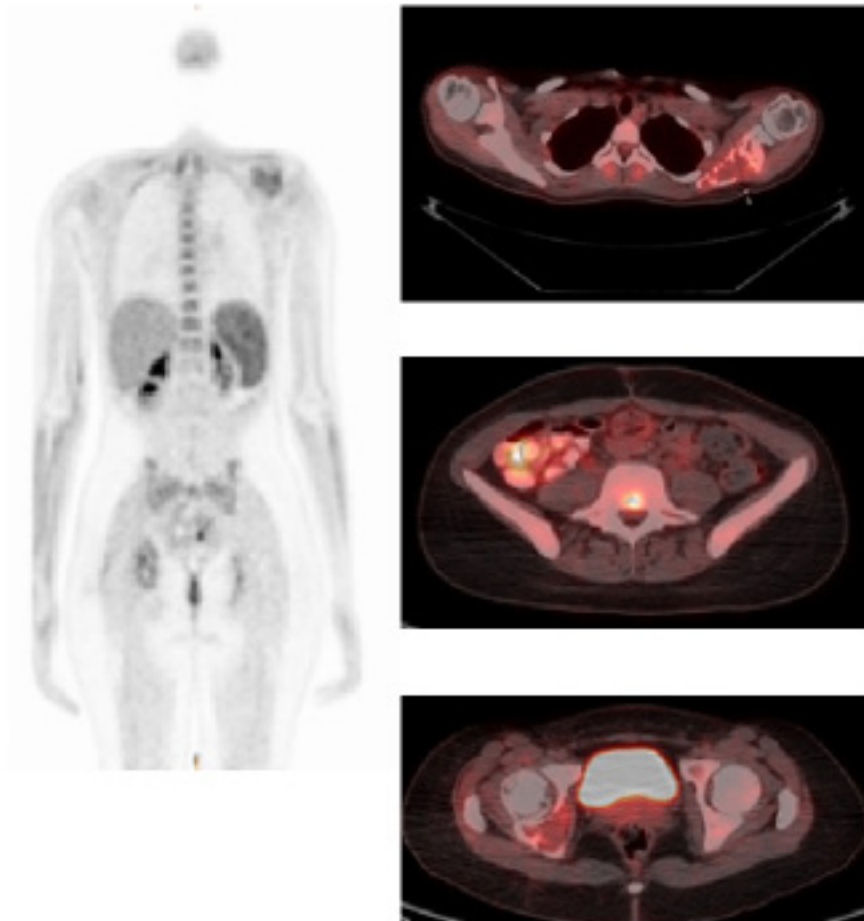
PET-CT scan (2011)
